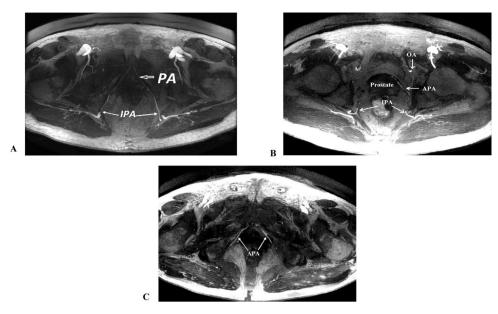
Patterns of penile arterial blood supply, by MRI high-resolution 3DT1, MIP (Maximum Intensity Projection): (A) type I arising exclusively from IPA; (B) type II arising from both APA and IPA; (C) type III arising exclusively from APA. IPA, internal pudendal artery; APA, accessory pudendal artery; OA, obturator artery; PA, penile artery.
